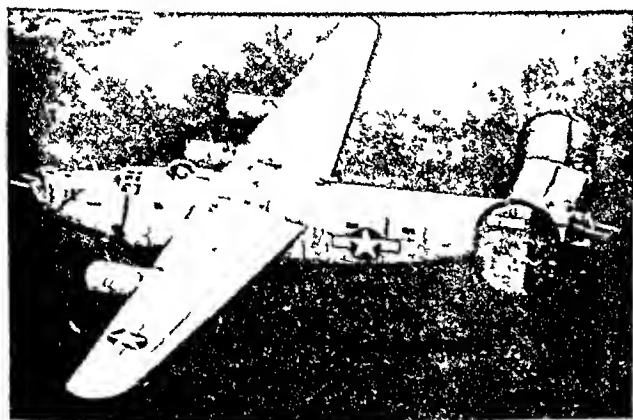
Use of airplane in transporting roentgen-ray equipment in World War II.
